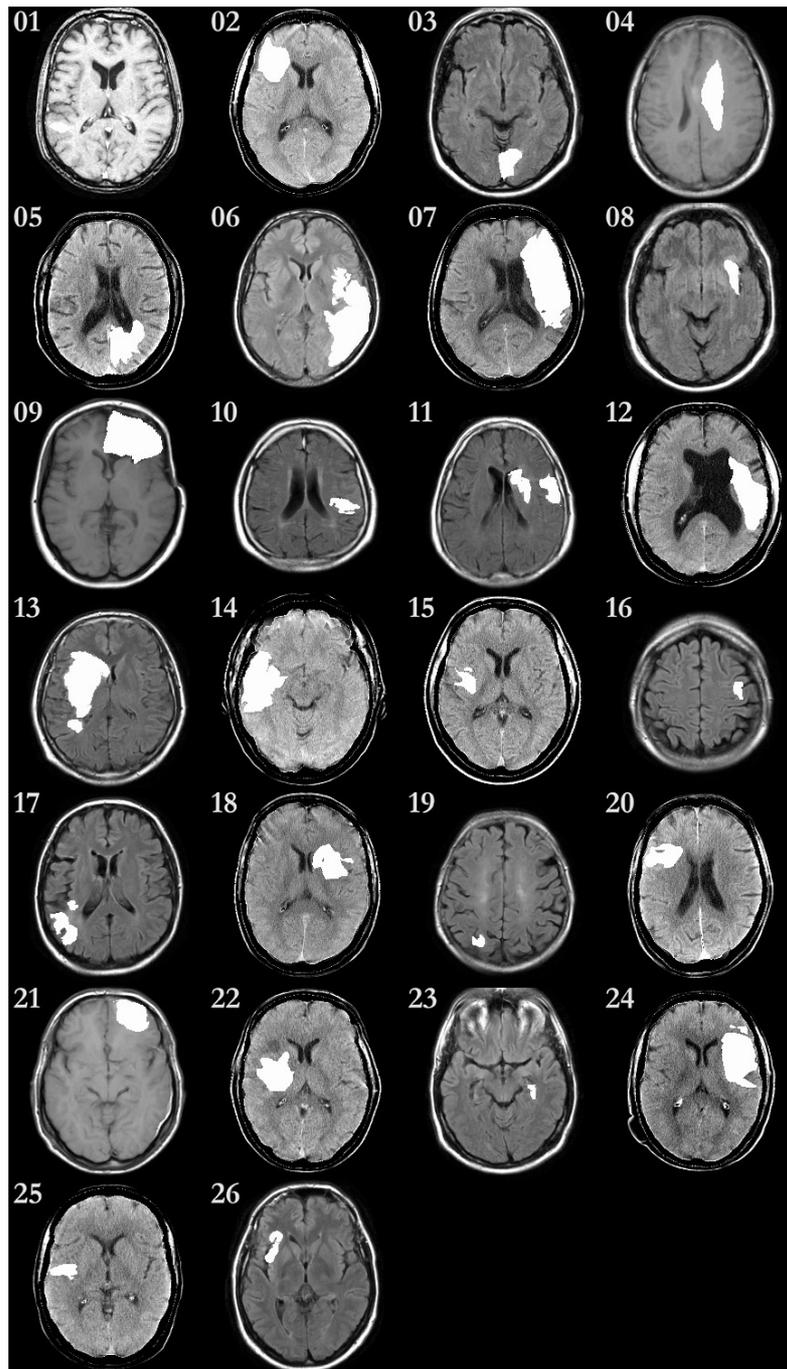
CT and MRI scans of the 26 patients after transformation to standard brain template.
